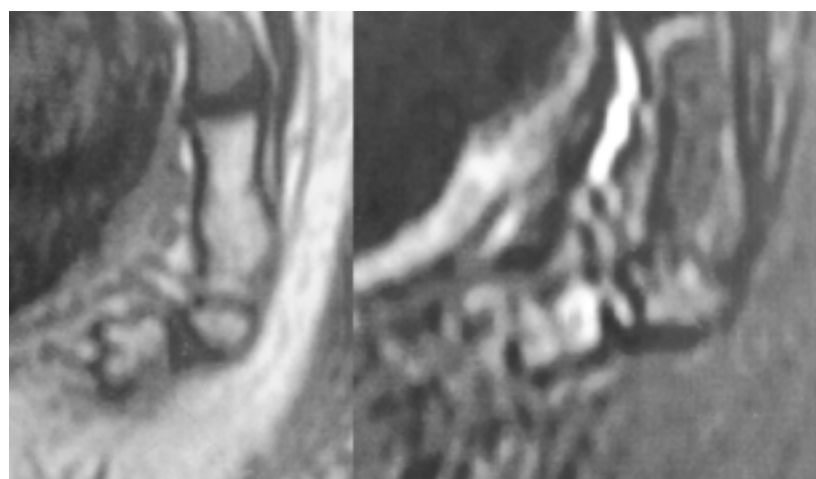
MRI performed 2 months after a fall in a 13-year-old boy. Sagittal T1 (left) and T2 STIR (right) sequence. T2 and also T1 hypersignal of the last caudal vertebra, showing inflammatory and haemorrhagic injuries (contusion). T2 hypersignal of the overlying disc showing the same lesions.
